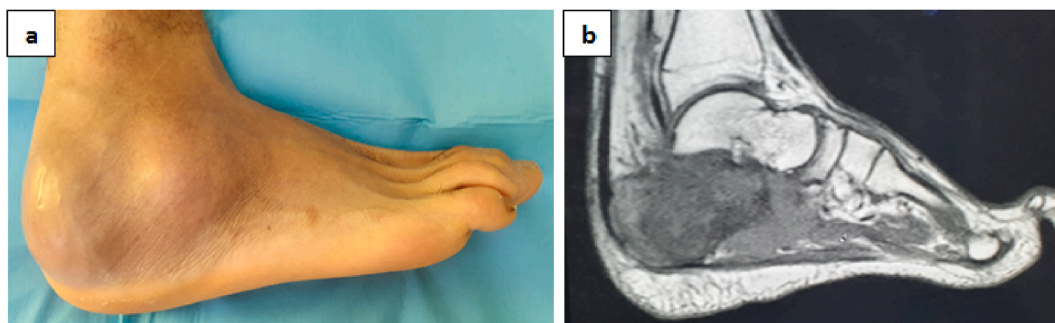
a. subcutaneous protrusion of tumor tissue in the hindfoot, b. MRI: Hyposignal T1 of the calcaneus.
